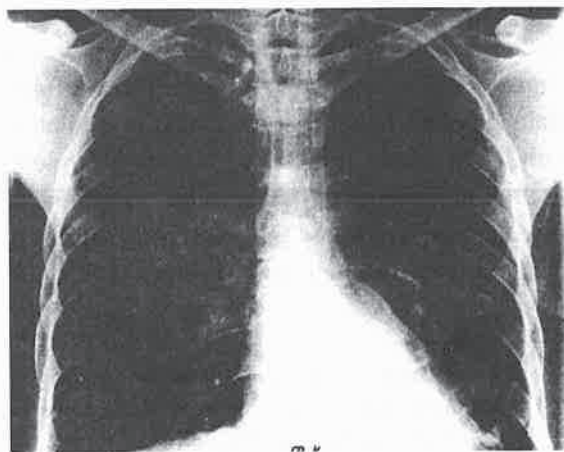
Chest roentgenogram showing reexpansion of the underlying lung following intrapleural streptokinase therapy.
